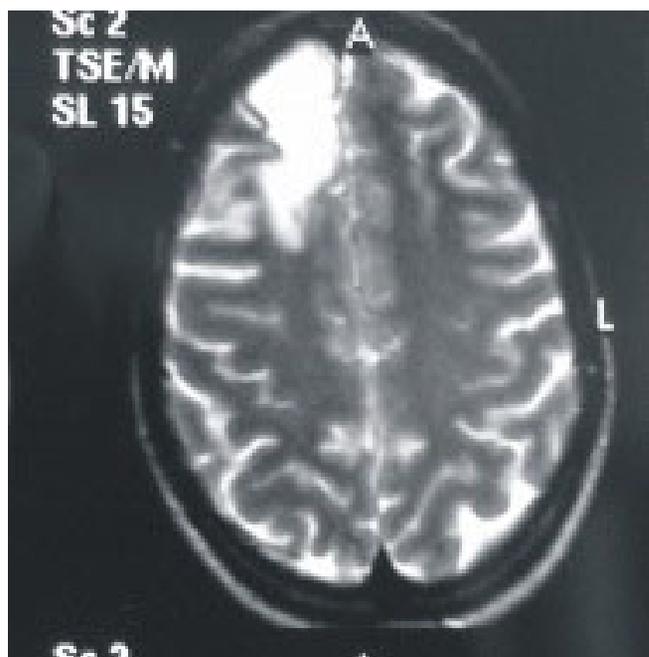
Recurrent astrocytoma. MRI demonstrates an abnormal increased signal (tumor mass) in the right frontal region.
